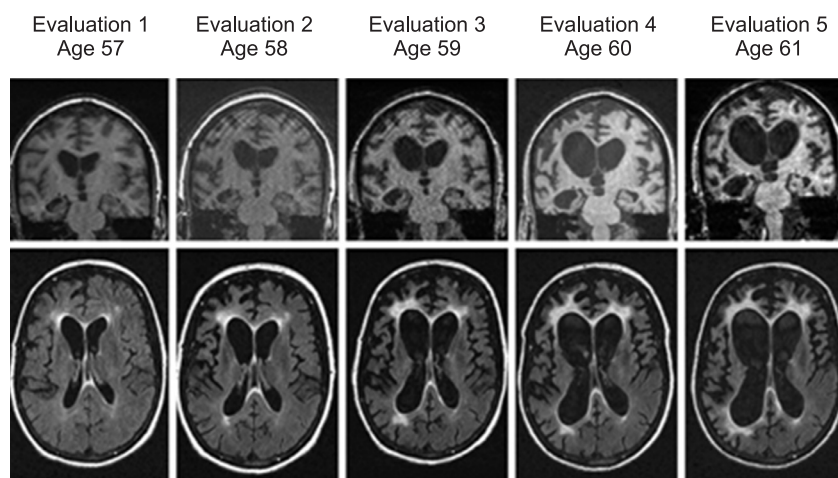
Progression of the FTD affected human brain - Longitudinal coronal T1-weighted images (top row) and axial fluid attenuation inversion recovery (FLAIR) images (bottom row) of the proband at Evaluations 1–5 (ages 57–61), demonstrating progressive right >> left frontotemporoparietal cortical and right hippocampal atrophy with progressive increased signal changes in the subcortical/periventricular white matter⁵
